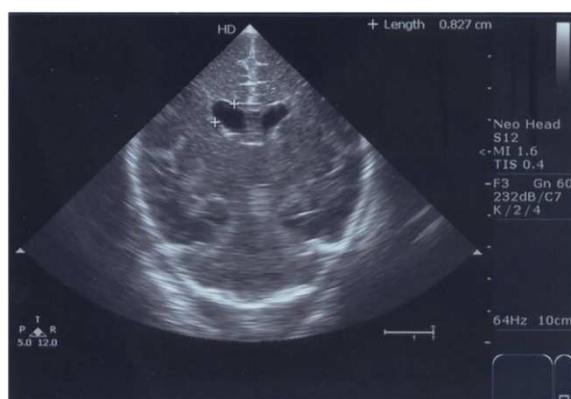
Cranial ultrasound coronal scan show cortical diffuse hypoechogenicity as well as dilated frontal horns of the lateral ventricles
